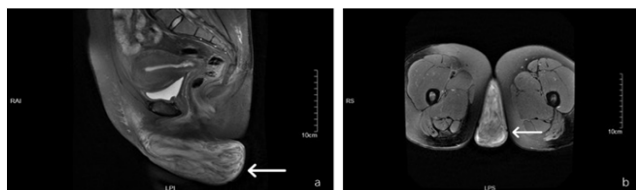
MRI of the pelvis showing the perineal mass (white arrow).
